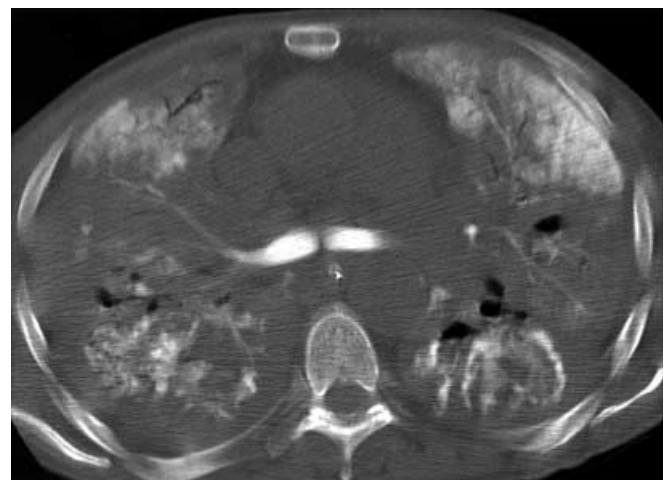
Patient with ECMO-induced thrombocytopenia after 13 days on ECMO. Partial liquid ventilation with perfluorocarbon was commenced in the hope of improving lung function enough to wean the patient from ECMO support. CT of the mid-thorax, showing the distribution of perfluorocarbon in lungs and airways shortly after instillation
